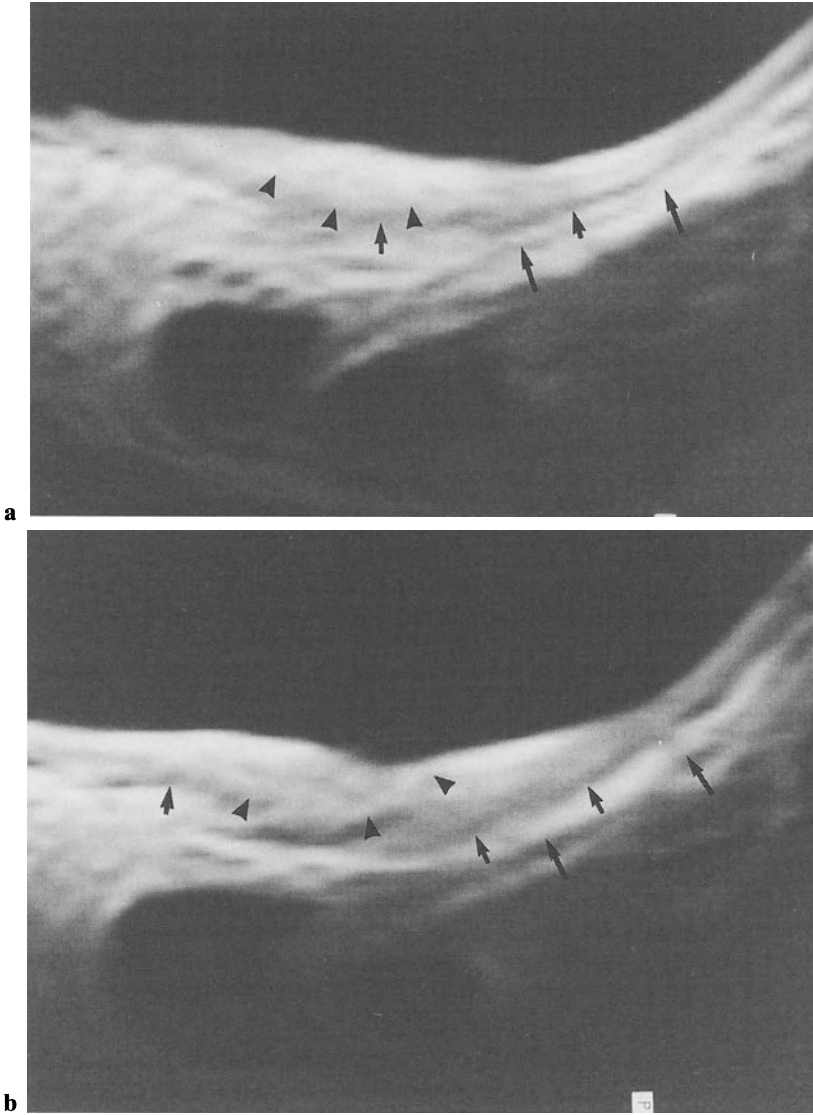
Eight weeks after electrolaser resection. The endorectal surface coil image demonstrates again a clear visualization of the different rectal layers. a,b The T1-weighted image (TR/TE = 700/15) taken after administration of 0.1 mmol/kg body wt. Gd-DTPA shows a slight increase of signal intensity and an edematous infiltration of the parts of the submucosa (*black arrowheads*). Muscularis propria (*short black arrows*), perirectal fat (*long black arrows*)
